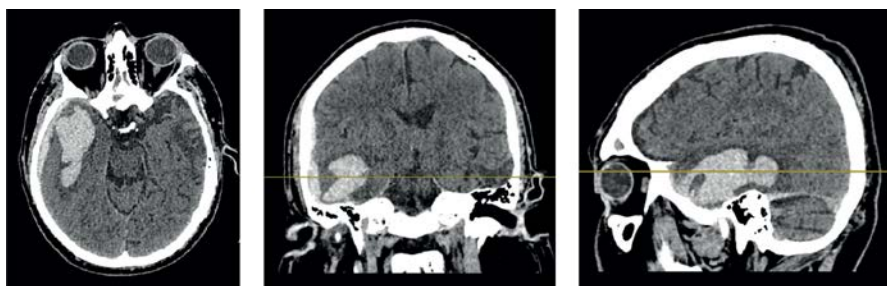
Brain CT scan of patient H., 40 years old, on admission at the hospital
